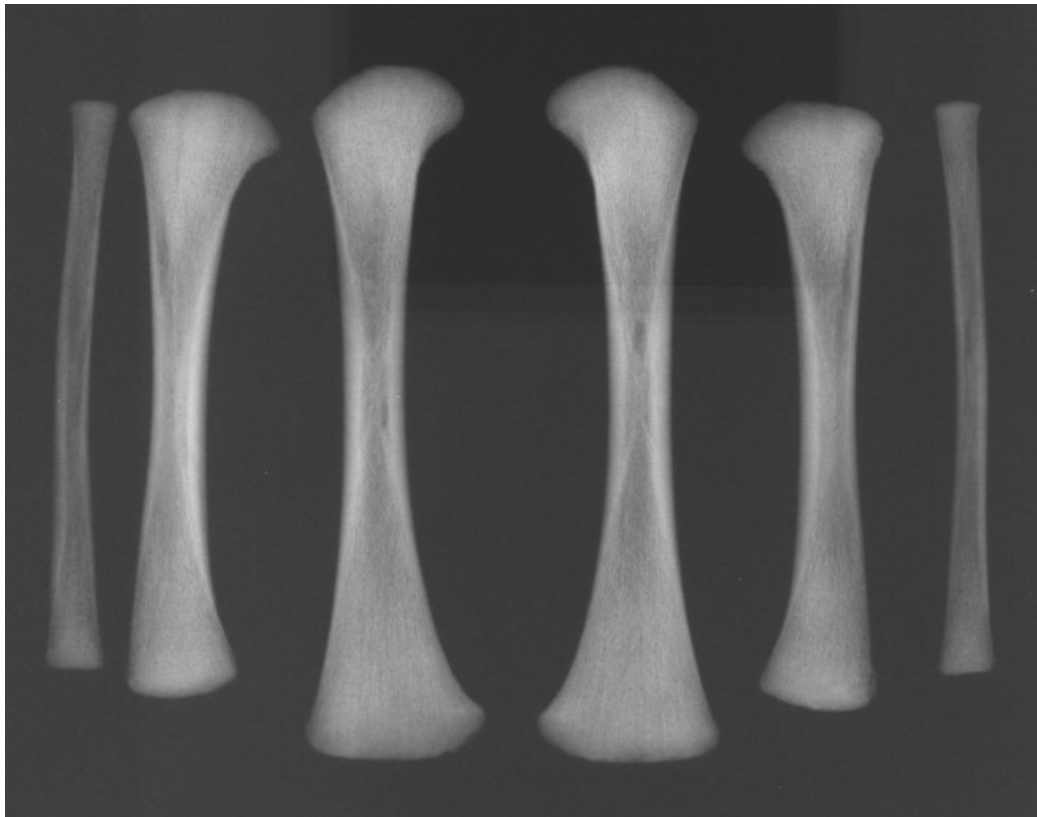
Radiograph of the femora and tibiae of Sk. 34.1 showing uniformity of the underlying trabecular structure.
